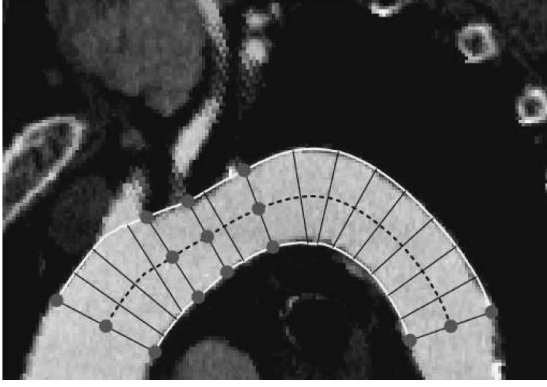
Projected 2-D plane showing the aortic arch of the first 3-D CTA dataset, where the centerline (dashed), the inner and outer contour (white), the points A, 1, 2, 3, and D, as well as several estimated diameters are marked.
